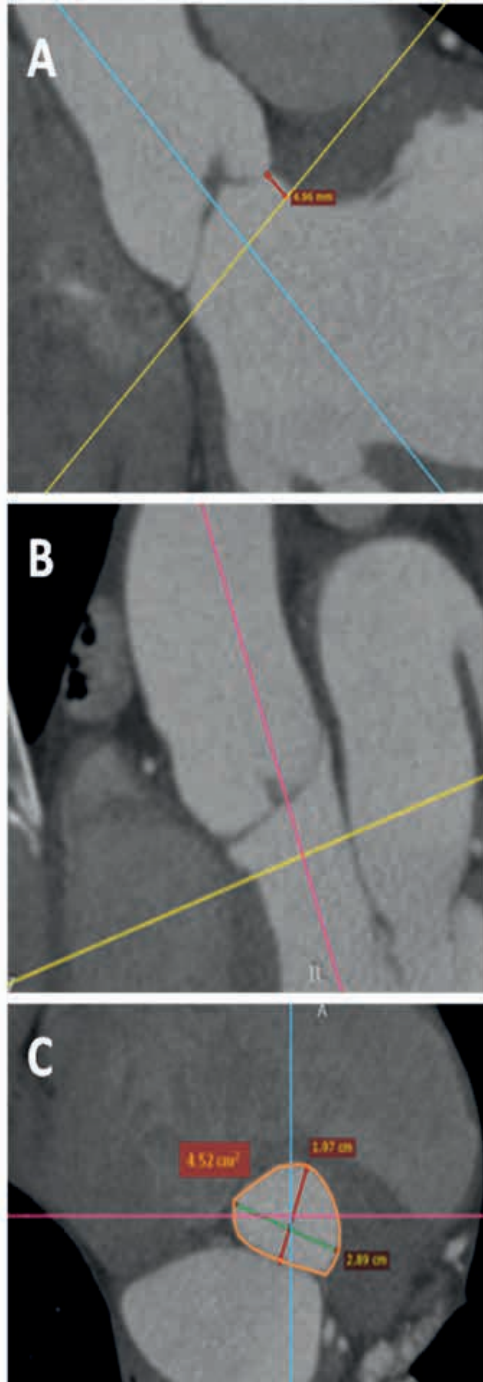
Cardiac multidetector computed tomography provides a 3-dimensional cardiac volume and by applying the tri-planar orthogonal system in the coronal (A) and sagittal (B) view at the level of left ventricular outflow tract (LVOT) ie 5mm below aortic annulus, the double-oblique view is created (C) where the real LVOT short axis can be seen. Then, the LVOT area can be accurately measured by planimetry of the area.
